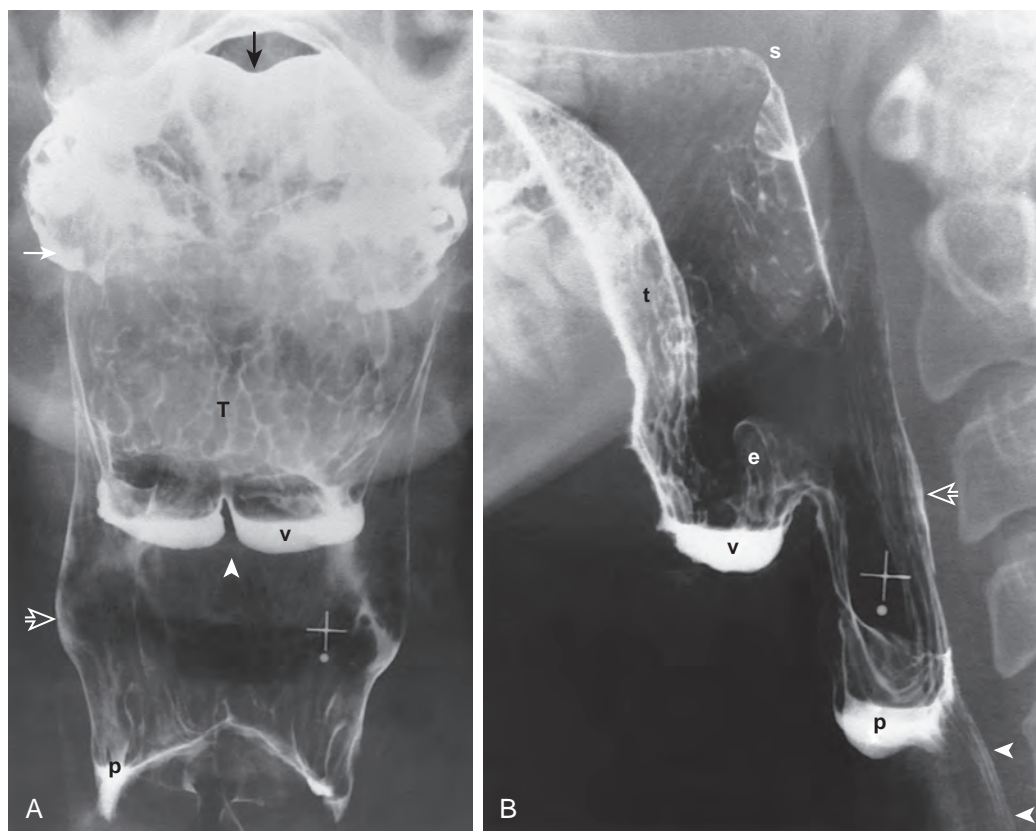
Basic structures of the normal pharynx. A. Double-contrast radiograph in the frontal view shows the contours of the superior surface of the tongue (*black arrow*), tonsillar fossa (right tonsillar fossa [*white arrow*]), valleculae (left vallecula [*v*]), and lateral wall (*open arrow*) of the piriform sinus (right piriform sinus [*p*]). The median glossoepiglottic fold (*arrowhead*) divides the space behind the tongue base into the two valleculae. The surface of the base of the tongue (*T*), seen en face, has a reticular appearance because of the underlying lingual tonsil.
